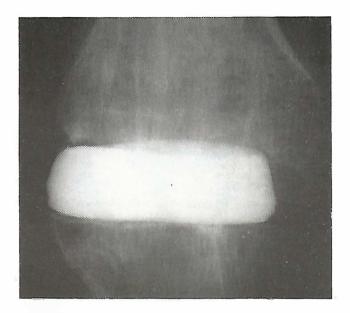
X-rays of knee AP view after bone cement block.
